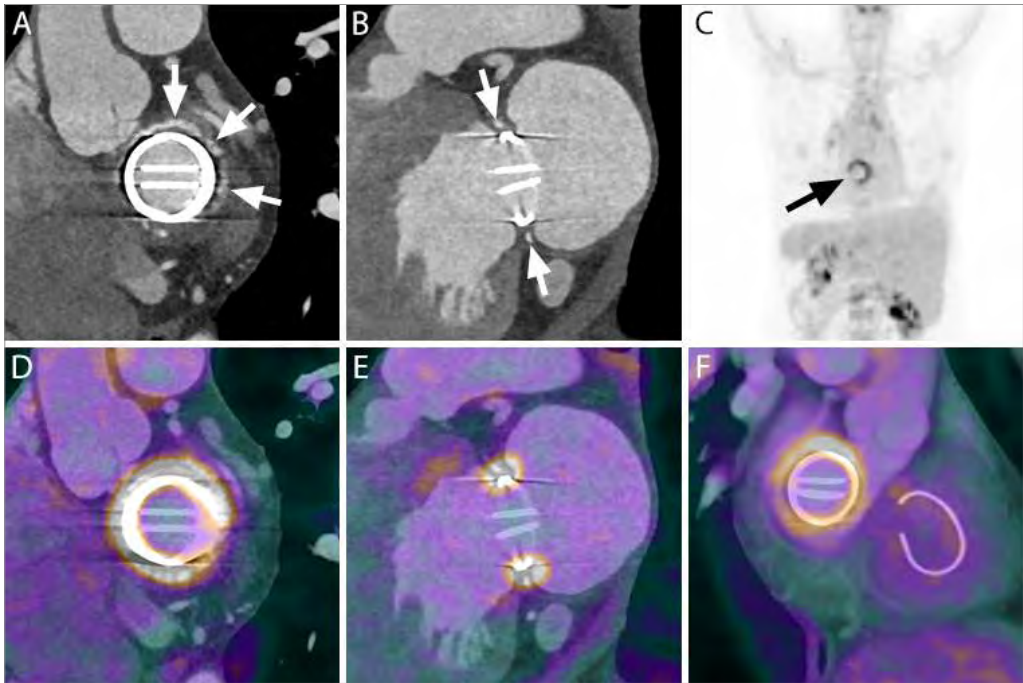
CTA (A, B), maximum intensity projection PET (C) and fused PET/CTA (D-F) of another patient with a mechanical mitral valve (St. Jude Medical, St. Paul MN, USA) and a tricuspid valve ring (plasty). Although the short axis view of the prosthetic valve may give the impression of extensive perivalvular extensions around the entire valve (A, arrows), the perpendicular view shows that there is no paravalvular connection (B, arrows) and that these areas therefore most likely represent surgical felt pledgets (see *Figure 5*; a non-contrast enhanced scan was not performed in this patient). The fused PET/CTA images however, clearly show diffuse highly increased ^{18}F -FDG uptake around the entire mitral valve prosthesis, confirming the diagnosis of PVE, while the tricuspid valve ring is completely unaffected. This patient was found to have chronic Q-fever and was treated conservatively.
